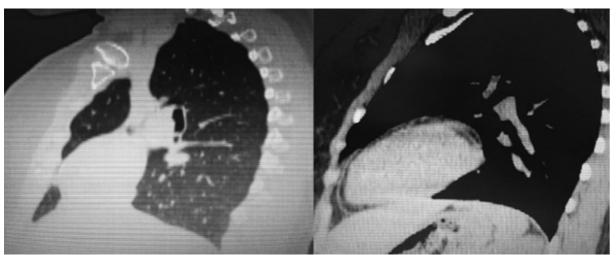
Axial CT scans: transposition of the main vessels in the upper mediastinum: aorta, v.cava sup. et pulmonary trunc.
